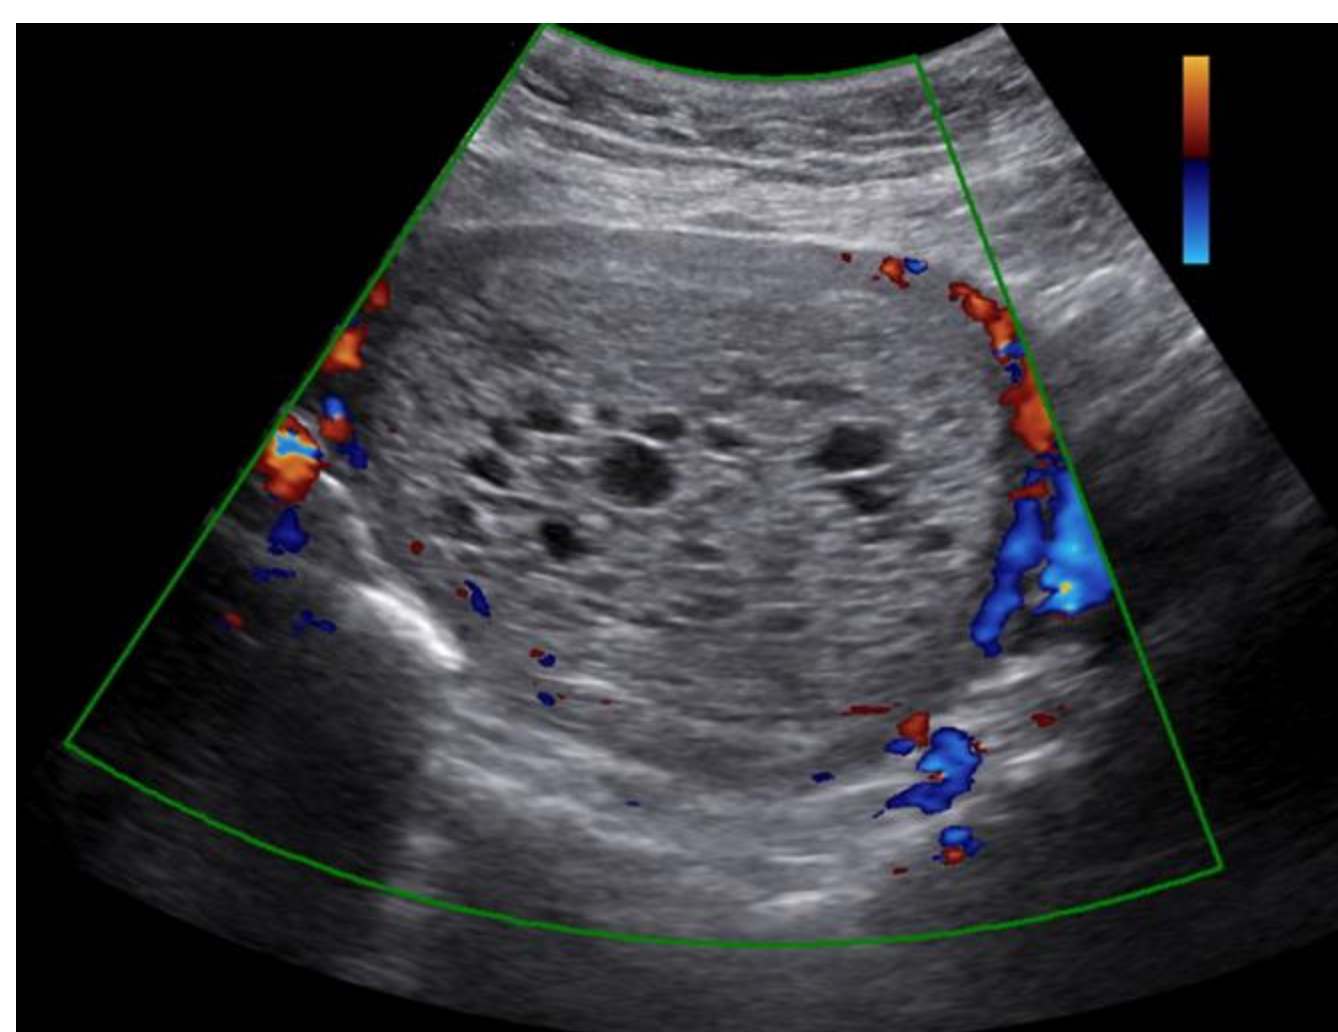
Ultrasound depicting the classic "snowstorm" or "cluster of grapes" appearance of molar pregnancy and decreased blood flow with color flow Doppler sonography.<sup>5</sup>
